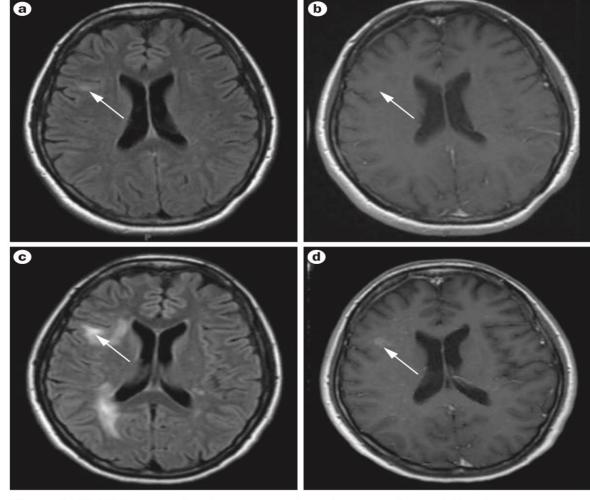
FLAIR images showing progression of progressive multifocal leukoencephalopathy immune reconstitution inflammatory syndrome. a | Multifocal, high-signal-intensity lesions (arrow) in the right hemisphere of a patient after prolonged immunosuppressive therapy for a lung transplant. The cerebrospinal fluid was positive for JC virus. b | Contrast enhancement is not evident (arrow) in immune reconstitution inflammatory syndrome lesions. c | 6 weeks later, progression of the white matter lesions (arrow) shows involvement of the uncinate fibers. d | Patchy enhancement with gadolinium (arrow) is noted (predominantly in the right hemisphere), which is indicative of immune reconstitution inflammatory syndrome. Abbreviation: FLAIR, fluid-attenuated inversion recovery.
